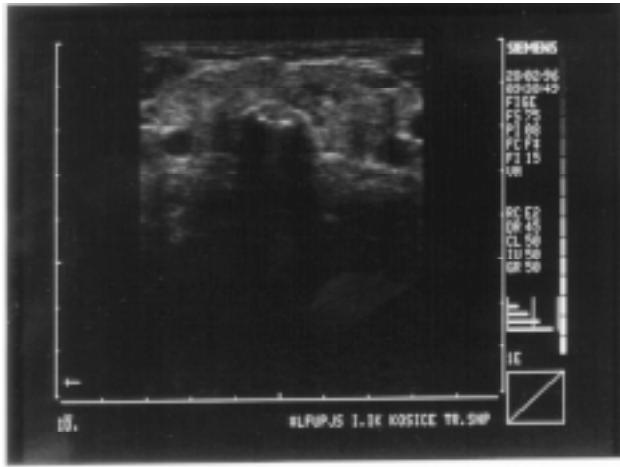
Ultrasound scanning of the thyroid. Hypoechoogenicity and inhomogeneity.
